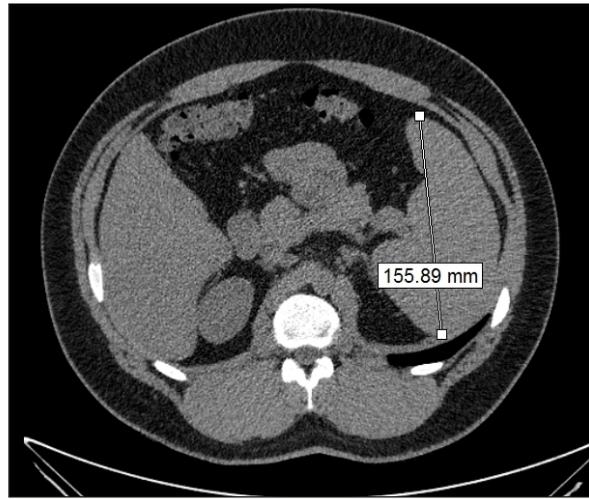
Abdominal CT scan showing enlarged spleen in a patient with SARS-CoV-2 and dengue virus coinfection.
